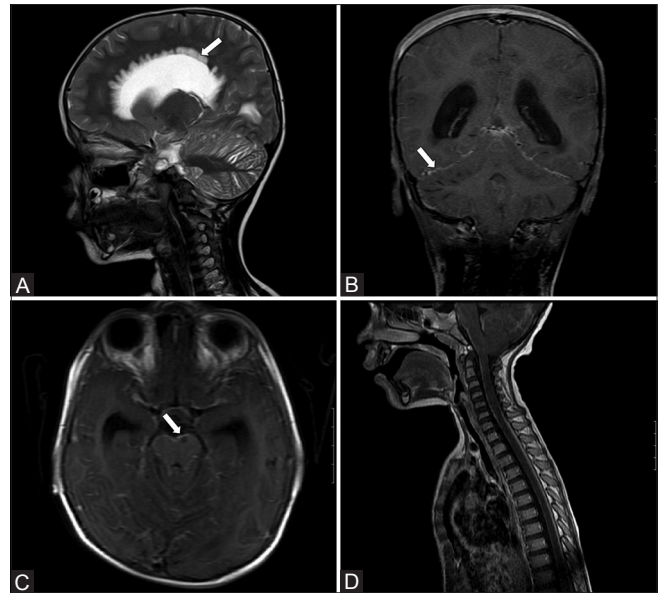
(A-D): (A) MRI findings (April 2013): T2 sagittal image shows periventricular white matter hyperintensity (straight arrow) (B) T1-weighted post contrast images show diffuse leptomeningeal enhancement (staright arrow) (C) T1-weighted post contrast images show diffuse leptomeningeal enhancement (staright arrow) (D) MRI spine screening appears relatively normal and is given for comparison with the follow up MRI
